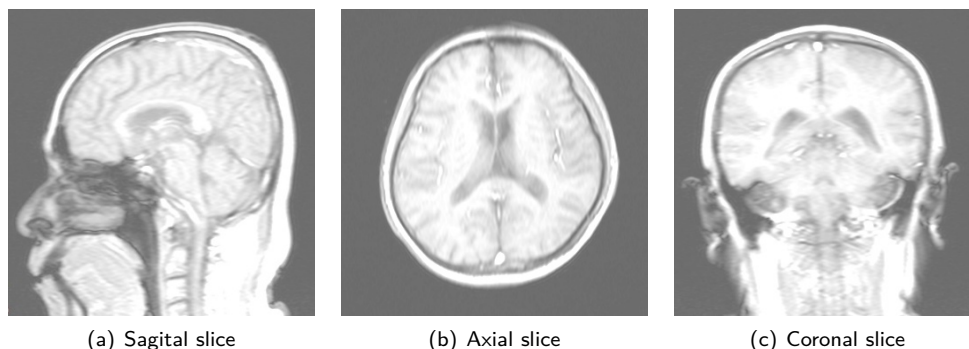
Head MRI slice views
